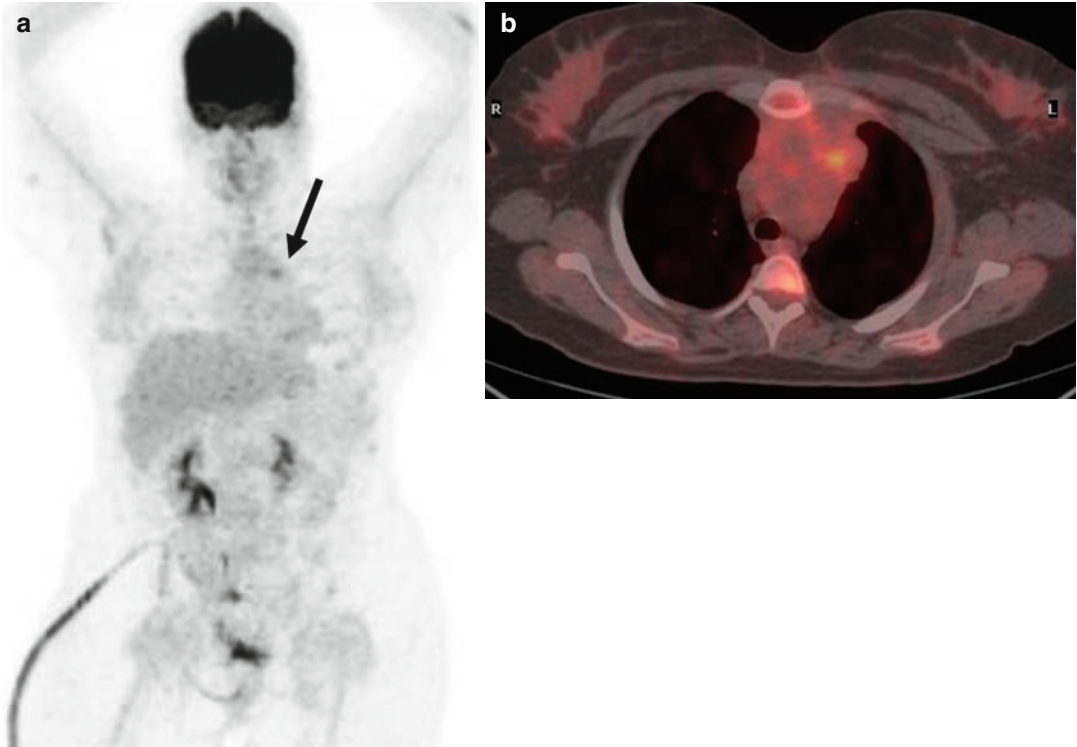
(a, b) MIP-PET and fused PET/CT post autologous transplantation: moderate ^{18}F FDG uptake at the residual mediastinal mass (*arrow* in the MIP image) (SUV_{max} 4.5)
